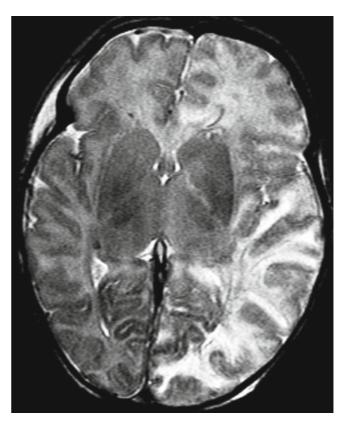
T1 MRI: multifocal ischemic infarction of the left side of the brain in incontinentia pigmenti
